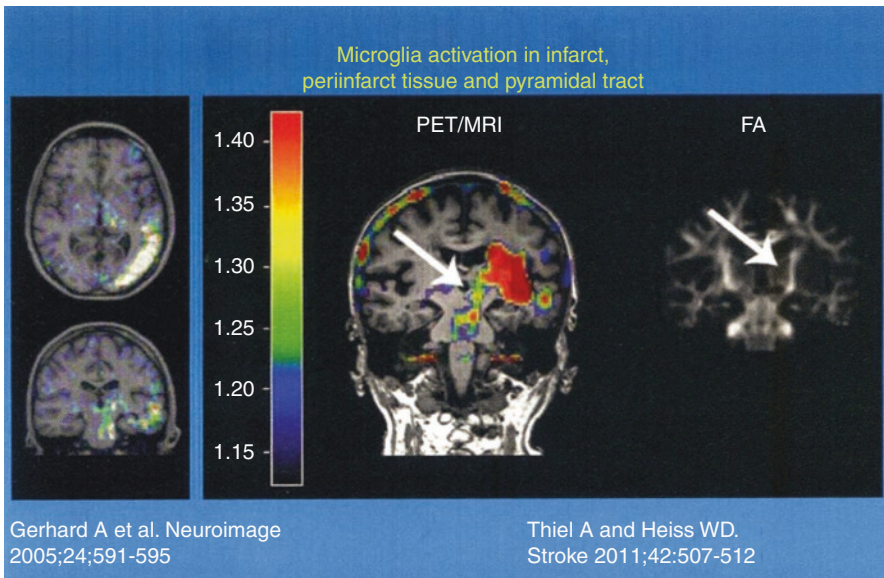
Microglia activation in infarct, peri-infarct areas (left; modified from Gerhard et al. 2005), and in remote fiber tracts imaged by ^{11}C -PK11195-PET (right; from Thiel and Heiss 2011): ^{11}C -PK11195-PET overlaid on T1-weighted MRI (left) and fractional anisotropy image showing fiber tracts (right). Tracer binding is high in the infarct but also follows the pyramidal tract (white arrows) in an antero- direction to the level of the pons (scale indicates uptake ratios)
